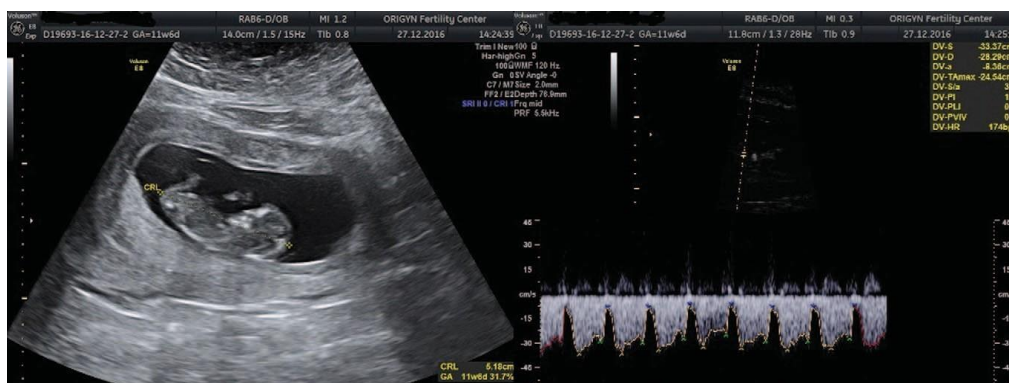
Ultrasound examination at 11 weeks showing a normal appearance of the placenta, normal ductus venosus flow, and CRL corresponding to gestational age
